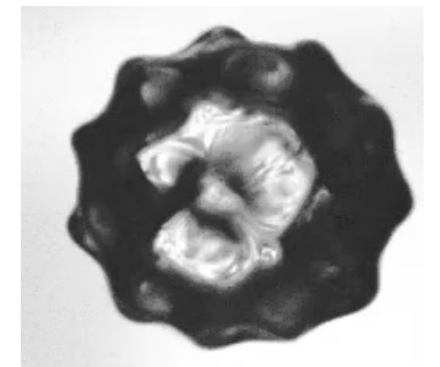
A bubble containing ultrasonically-induced surface waves which move rapidly over the bubble surface, 'scrubbing' the surroundings.
